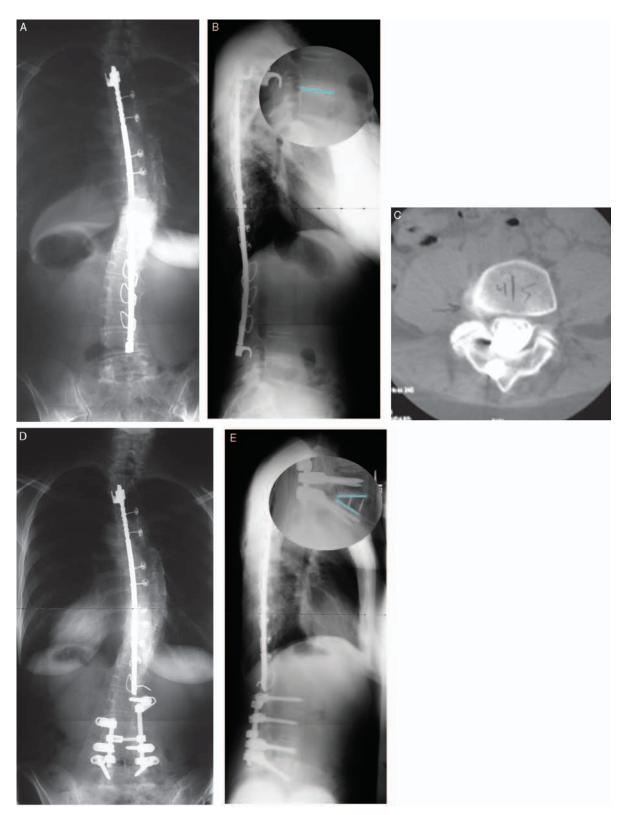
A 35-year-old woman with idiopathic scoliosis who had undergone posterior spinal fusion and Harrington instrumentation from T3-L4 in 1984. She had a history of chronic low back pain and right anterior thigh pain for 6 months. Anteroposterior (A) and lateral (B) radiographs demonstrate lumbar flatback deformity, sagittal imbalance, and adjacent segment degeneration at L4-5. Axial CT myelogram at L4-5 (C) demonstrates right foraminal stenosis. She had a positive discogram with concordant pain at L4-5, with a negative control at L5-S1. She underwent L4-5 XLIF, followed by partial removal of the Harrington rod, L3-5 laminectomies and foraminotomies, and posterior fusion and pedicle screw instrumentation, L2-5. Postoperative anteroposterior (D) and lateral (E) radiographs demonstrate restoration of segmental lordosis (inset).
